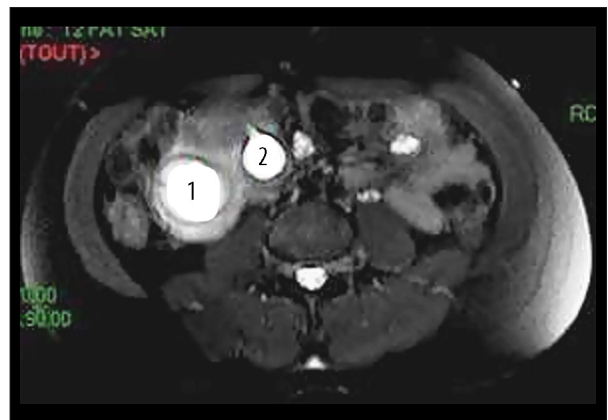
MRI T2-weighted 2015: Gastric duplication cyst (1): Diabolo, (2): Pancreatic extension).
